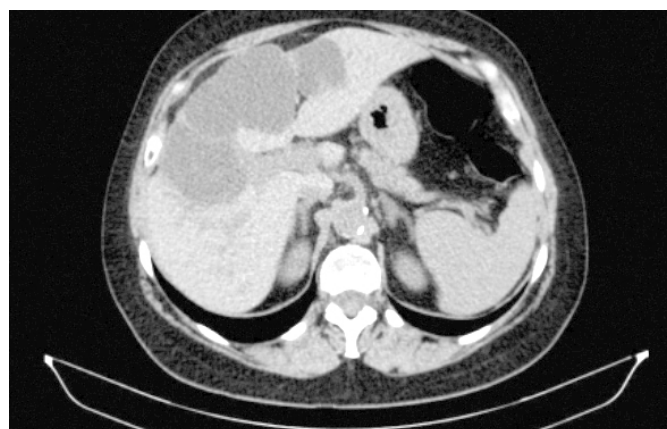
Abdomen CT scan case 3.
